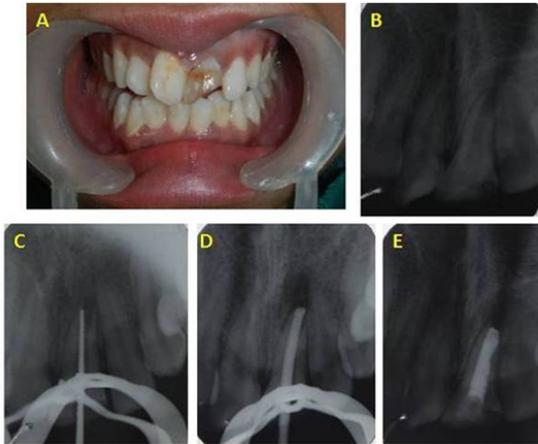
(a) Preoperative (b) Preoperative radiograph of tooth 21 (c) Working length radiograph of tooth 21 (d) MTA apical plug of tooth 21 (e) Tailor made gutta percha of tooth 21 (f) Post-obturation radiograph.
